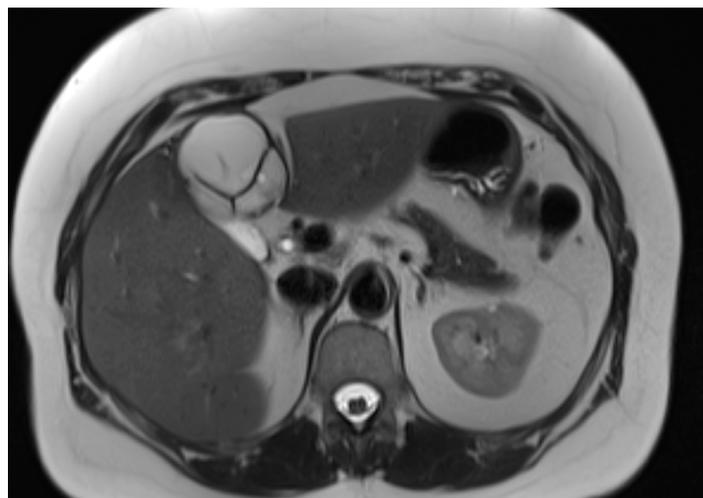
MRI pictures showing BCA with septations and nodule.
